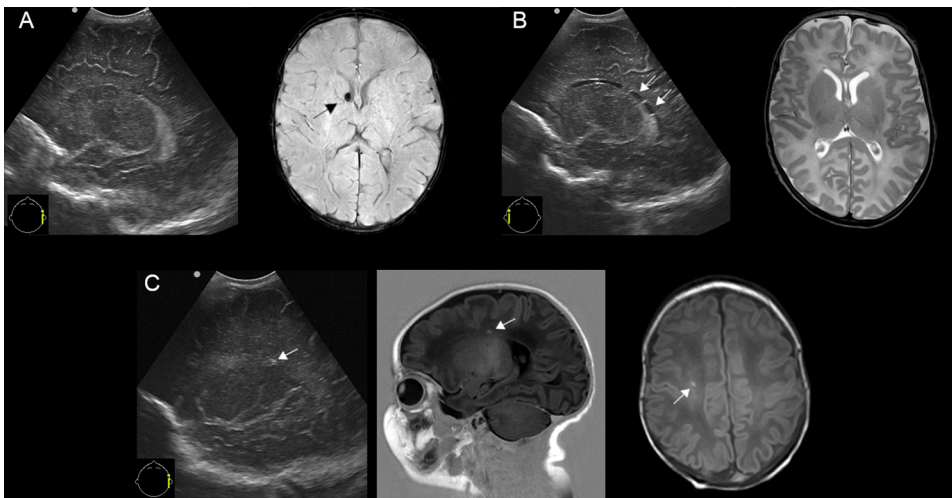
Comparisons between cUS and MRI. A) Sagittal view of a TEA-cUS with no signs of IVH, while SWI shows a low signal intensity, representing remnants of an IVH. B) Several choroid plexus cysts are seen on the sagittal view of the TEA-cUS, while this is not depicted by T2-weighted MRI. C) A small punctate inhomogeneous lesion suspected for a PWML is seen in the frontal lobe on the sagittal view of the TEA-cUS, corresponding to a high signal on the sagittal inversion recovery T1-weighted image and transverse T1 weighted image.
